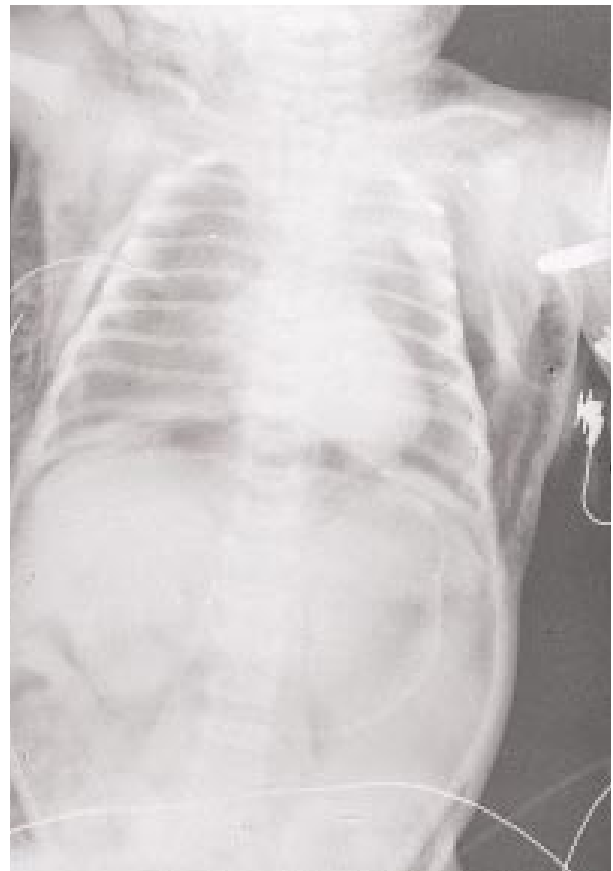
Chest and abdominal radiograph in an infant with massive air leak. Note the pneumothorax, pneumomediastinum, pneumoperitoneum and subcutaneous emphysema. This problem occurred as a result of the use of excessive pressures in ventilating the infant.
